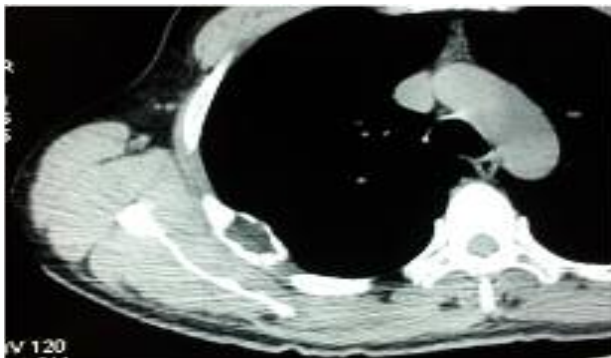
CT scan of the thorax: osteolytic and sharply demarcated mass arising from the posterior arch of the right fourth rib. Fat attenuation was observed which suggested the adipose nature of the tumor.
